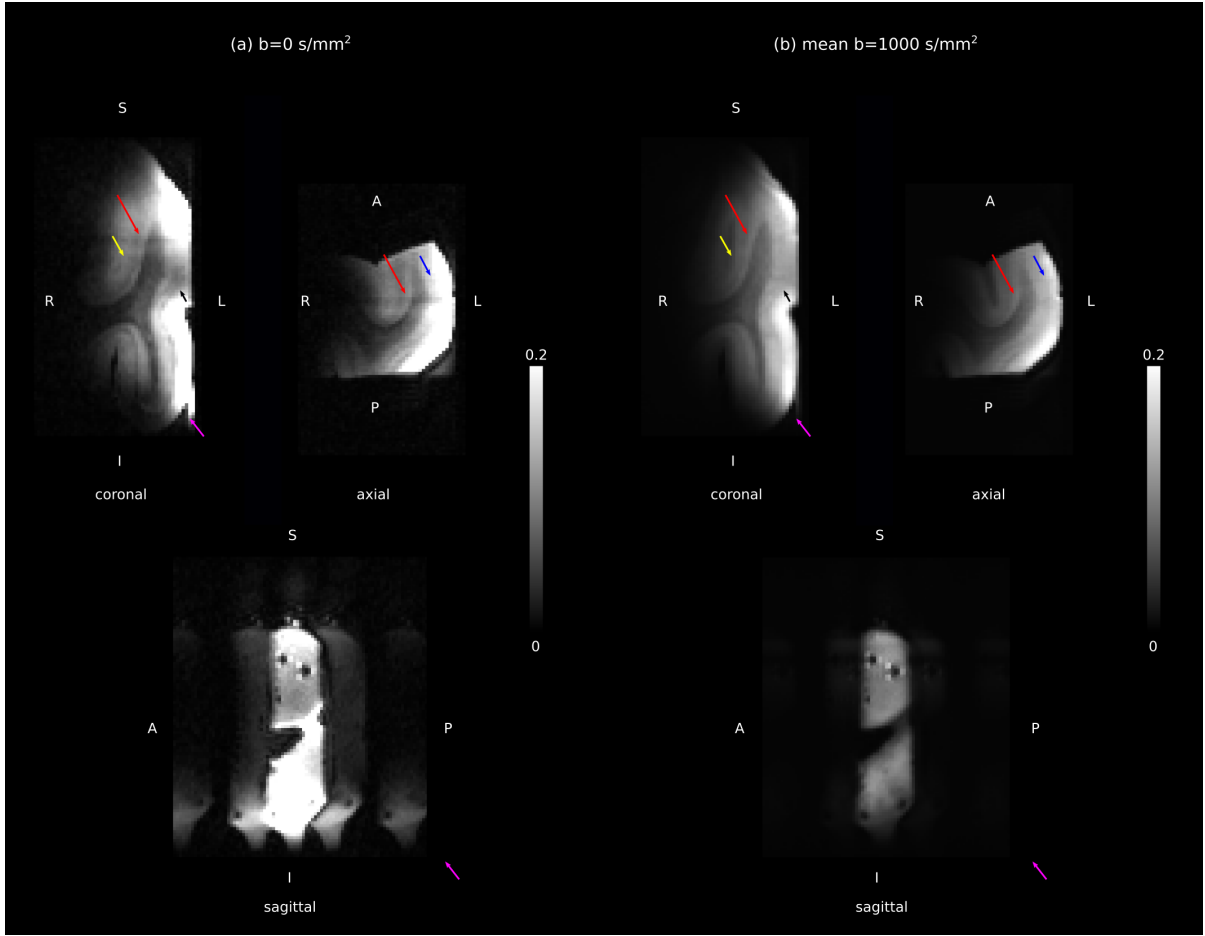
The $b = 0 \text{ s/mm}^2$ images *post mortem* were affected by localised artifacts and hence removed from the analysis. (a) A representative $b = 0 \text{ s/mm}^2$ image from the DWI series showing the artifact on coronal, axial and sagittal slices in regions indicated by the arrows. (b) Mean $b = 1000 \text{ s/mm}^2$ image computed based on the entire DWI series shows negligible diffusion weighting and significantly reduced artifacts compared to $b = 0 \text{ s/mm}^2$. We used this image as a “pseudo $b=0$ ” image in the analysis. Arrows of the same colour point to the same location on all views. The ghosting artifact shown on the bottom panel in (a) and (b) would not have affected our results in the superficial white matter because it was located far from it. A: anterior, P: posterior, I: inferior, S: superior, L: left, R: right
